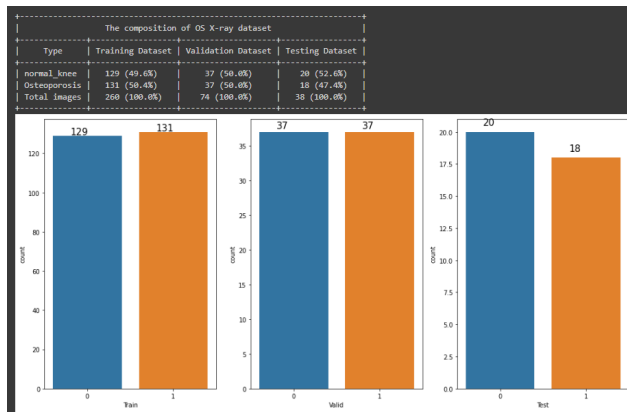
Knee Osteoporosis X-Ray image data distribution
